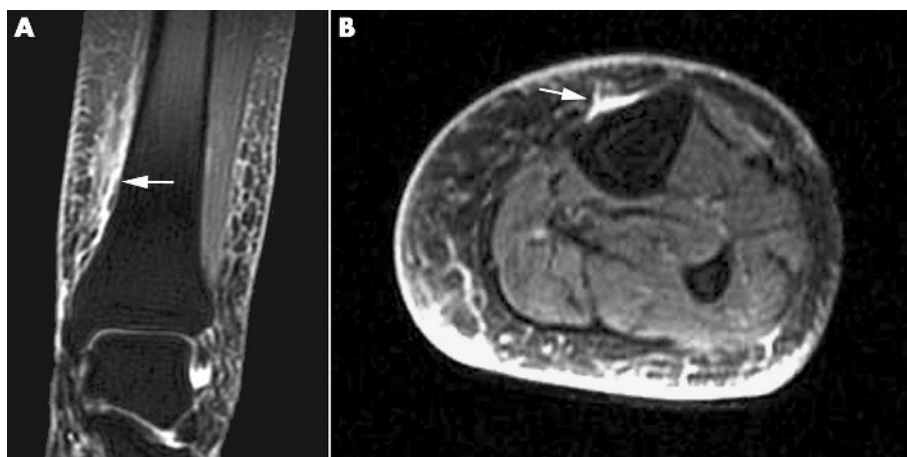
Magnetic resonance imaging of distal tibia. Coronal (A) and axial (B) fat suppressed, T₂ weighted, fast spin echo images show hyperintense signal intensity along the medial surface of the tibia corresponding with periosteal oedema (arrows). No cortical or marrow abnormality was demonstrated.
